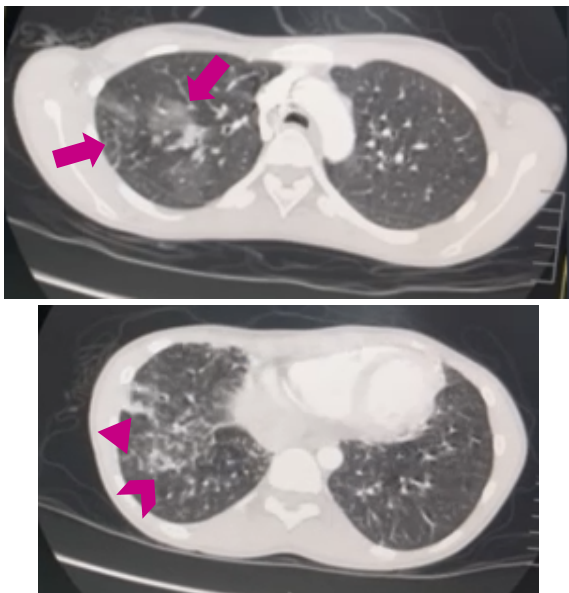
Chest computed tomography scan of a 16-year-old female diagnosed with pulmonary paragonimiasis, A) upper lobes; B) lower lobes (arrows: ground glass opacities; arrowhead: reticulonodular densities; triangle: worm tract sign)
